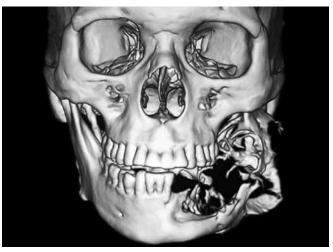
3D CT scan (frontal view)
